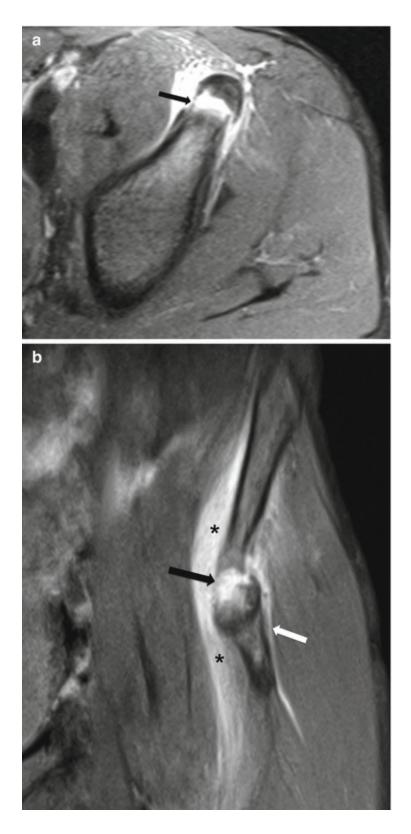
A 14-year-old male athlete with an acute avulsion fracture of the anterior inferior iliac spine. (a) Axial and (b) coronal fat-suppressed T2-weighted MRI show fracture of the anterior inferior iliac spine (black arrow), attachment site of the direct tendon of rectus femoris (white arrow). Note the presence of feathery edema of the iliacus muscle (asterisks)
